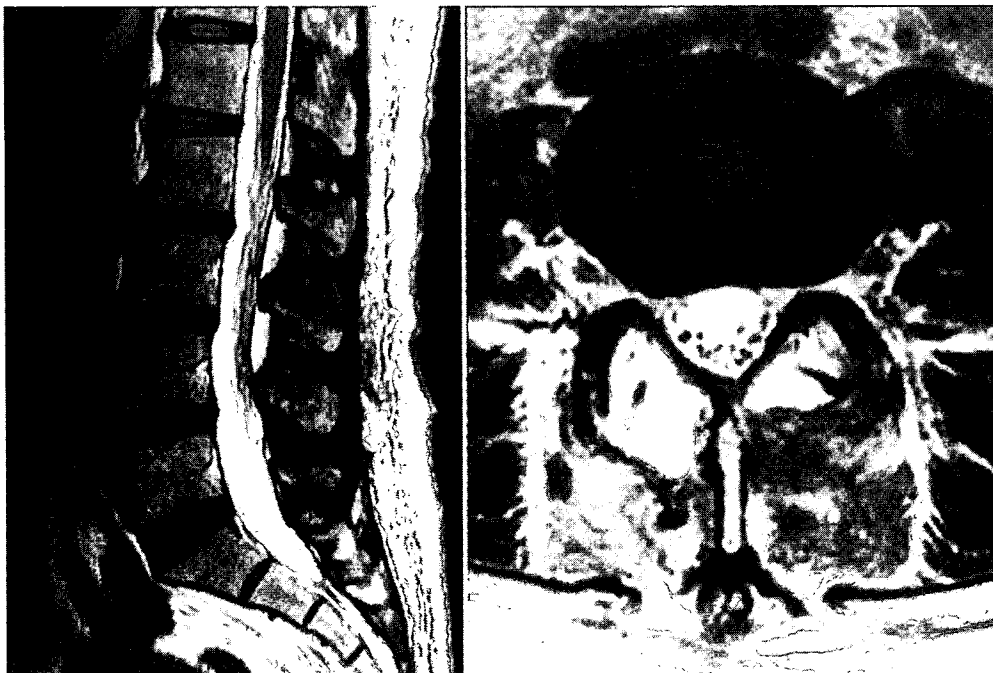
Postoperative T2-weighted sagittal (*left*) and axial (*right*) MR images showing complete removal of the masses and no compression of the dura mater.
